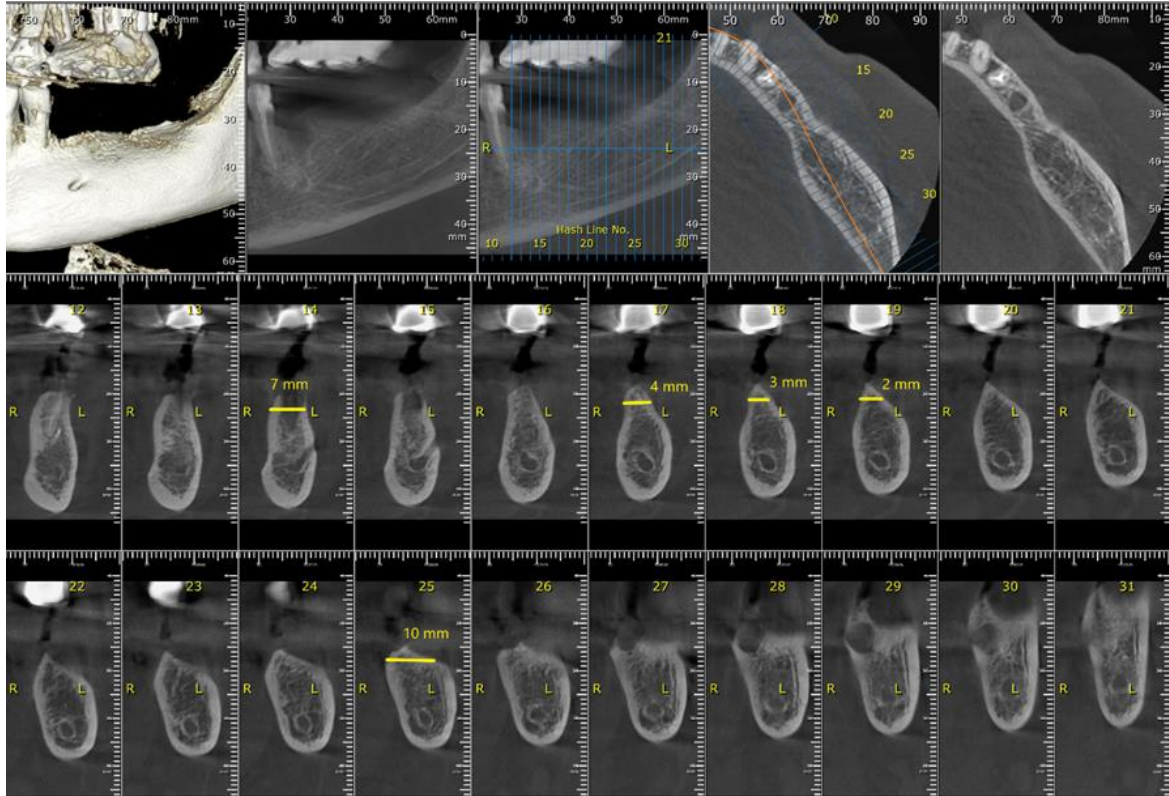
CBCT at the level of the left hemimandible
